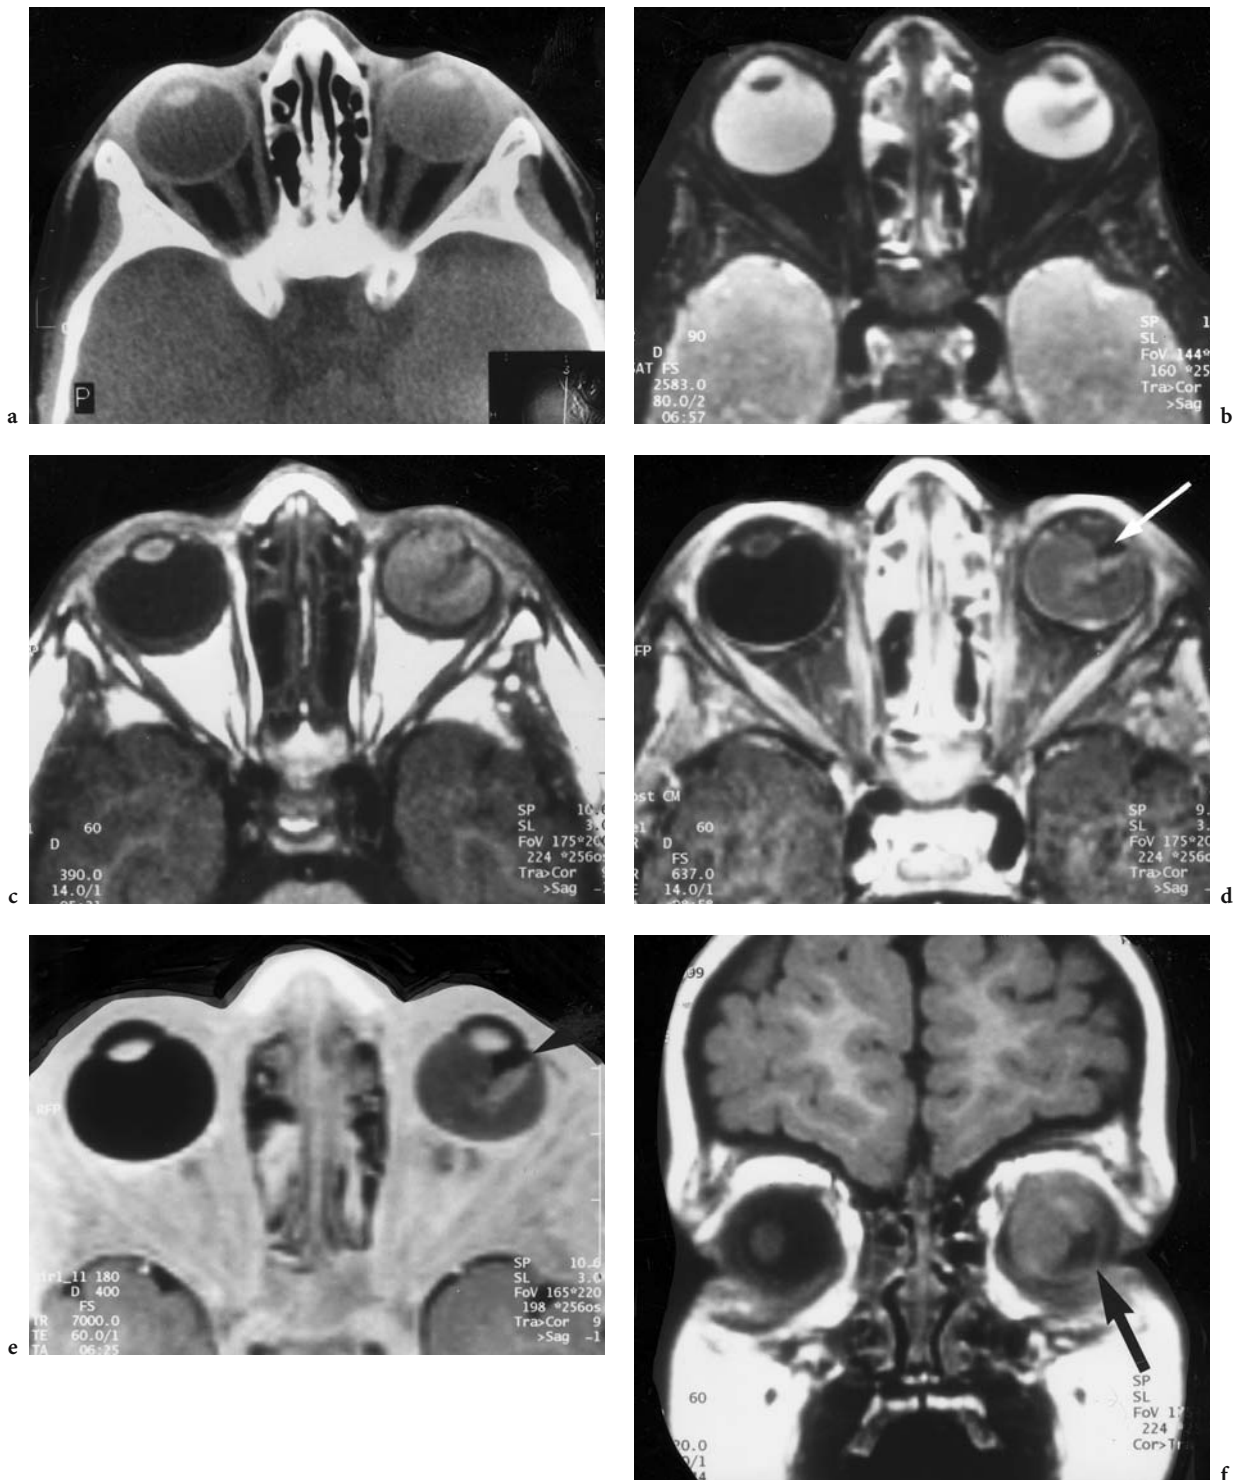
A 2-year-old boy presenting with leukokoria and complete retinal detachment of the left eye. Diagnosis: Coats disease. a CT: axial view showing only slight hyperdensity (43 HE) of the left globe; comparison with the right (15 HE). Note diminution of the left globe. b Axial T2-weighted image presenting the retinal detachment as a clearly defined, bilateral, biconvex, V-shaped hyperintensity in the left globe. The hyperintense region at the point of the angle may be an indication of slight hemorrhage. c Corresponding T1-weighted view with a relatively homogeneous signal of the subretinal fluid. d Corresponding contrast-enhanced (FS) view with slight signal enhancement of the detached retina. The remaining vitreous body (*white arrow*) is represented by a small area of hypointensity behind the lens. e Corresponding IR view yielding the most impressive image of the characteristic V-shaped, bilateral retinal detachment (*the arrowhead* points to the remaining vitreous body). f Coronal T1-weighted slice at the level of the remaining vitreous body (*arrow*), demonstrating the V-shaped retinal detachment and the presence of slight hemorrhage in the upper region
